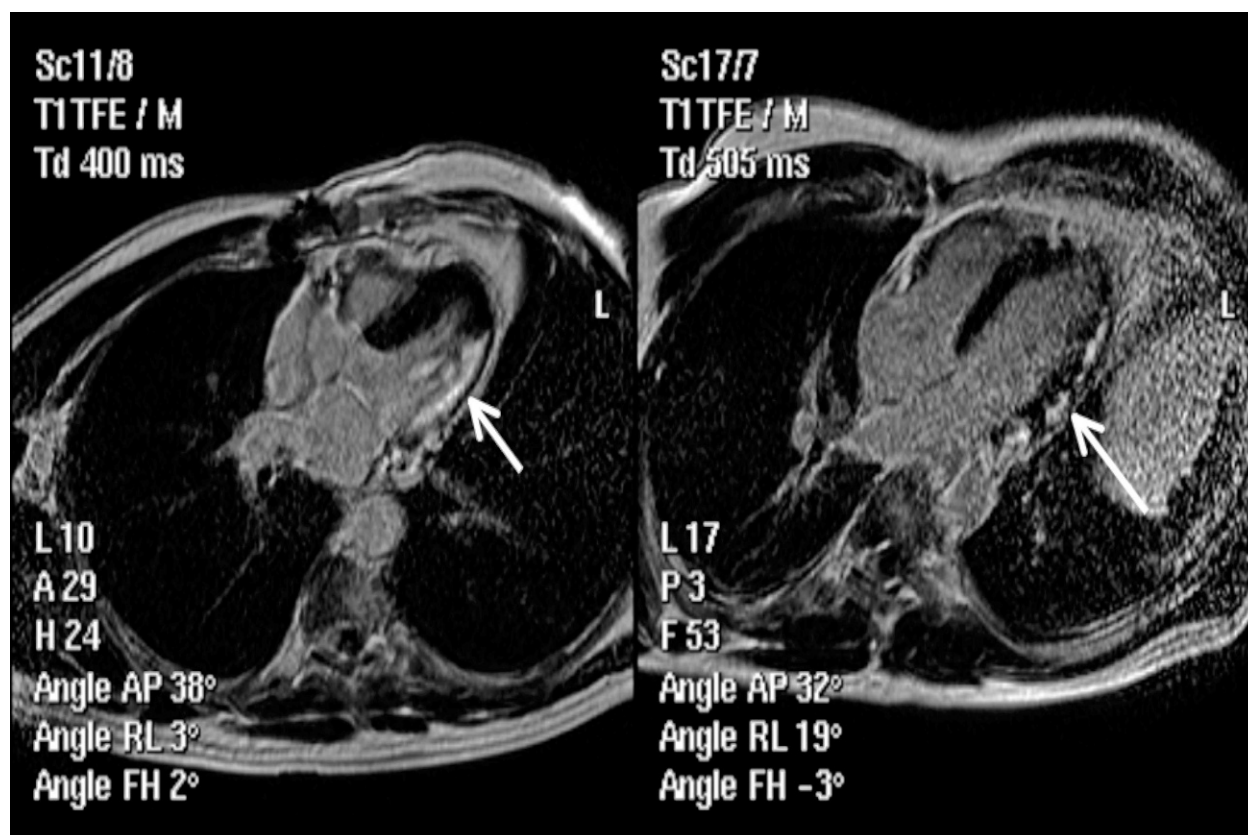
Case: 24-year-old male with chest pain, elevated troponin, and normal coronary arteries. Cardiac magnetic resonance imaging: delayed hyperenhancement (DHE). Diagnosis: Image on the left shows typical DHE (arrow) consistent with myocardial infarction (involving endocardium and sparing epicardium). Image on the right shows DHE (arrow) in this patient with myocarditis (involvement of epicardium only).
